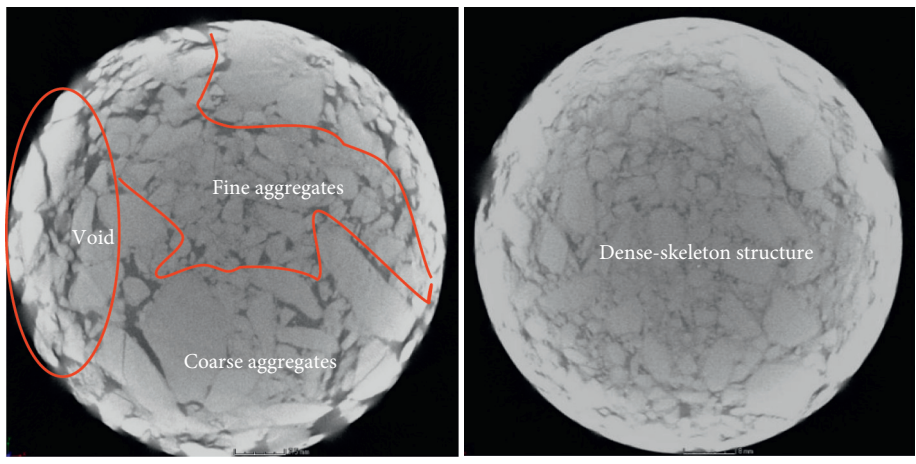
The X-ray CT test results of the circular cross section of cement-treated aggregates prepared by different mixing techniques.
